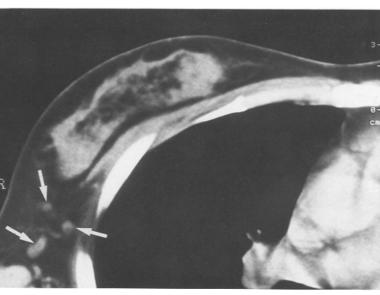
Metastatic axillary nodes imaged by ultrasound, CT, and DSA. a The right axillary nodes, 9 mm and 6 mm in size, are depicted on ultrasound but the image does not give sharp contrast to the subcutaneous fatty tissue (*black arrows*); b nodes up to 3 mm in size are clearly visualized on CT (*white arrows*); c the image by DSA is apparently inferior to that by ultrasound and CT (*black arrows*)
